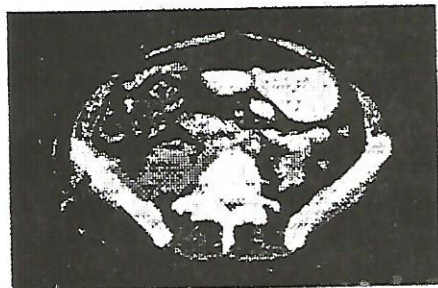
CT scan showing pus and gas within right psoas muscle
